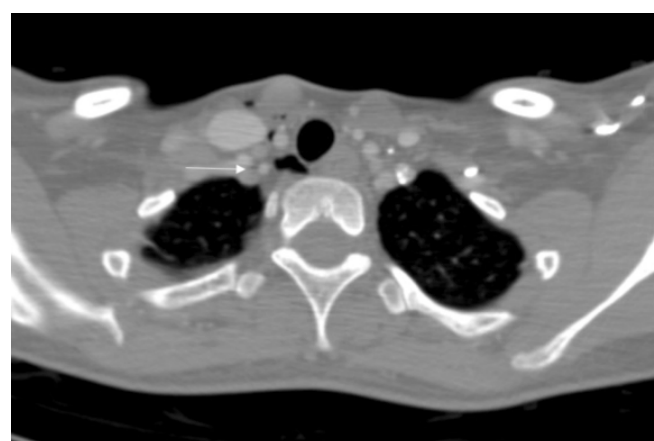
CT image showing air entrapped in the superior mediastinum.
